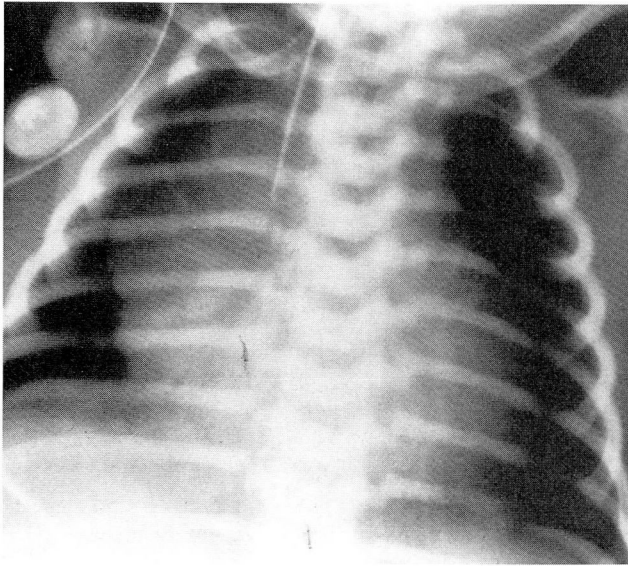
Anteroposterior chest radiograph demonstrating cardiomegaly with decreased pulmonary vascularity. The endotracheal tube is in place.
